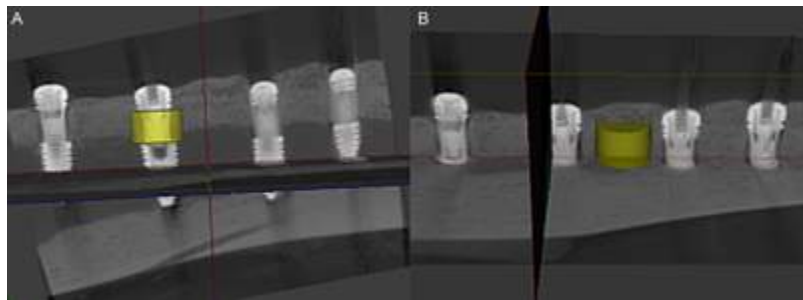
Representative sagittal μ CT slice showing scaffold-implants systems inserted into the tibia of minipigs after 8 weeks of healing time and the cylindrical volumetric region of interest (VOI), where measurements in peri-implant bone were made (A), at the level of the test zone and (B), at the level of reference zone.
